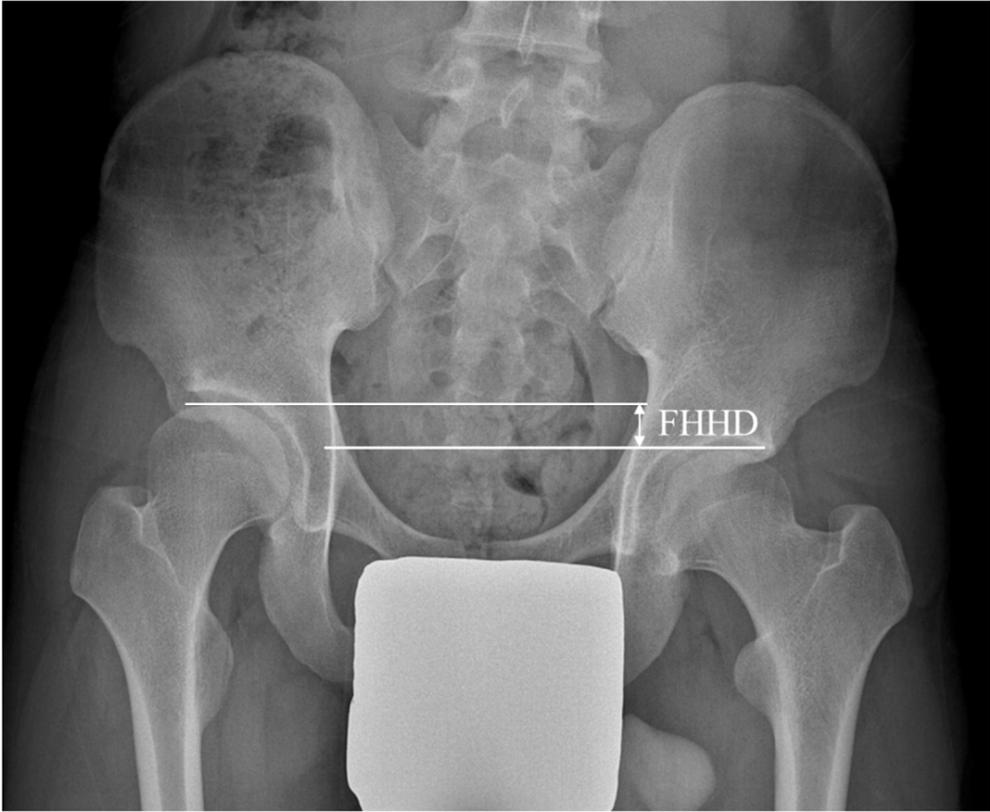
Measurement of the femoral head height difference (FHHD) on standing anteroposterior radiograph of the hip
